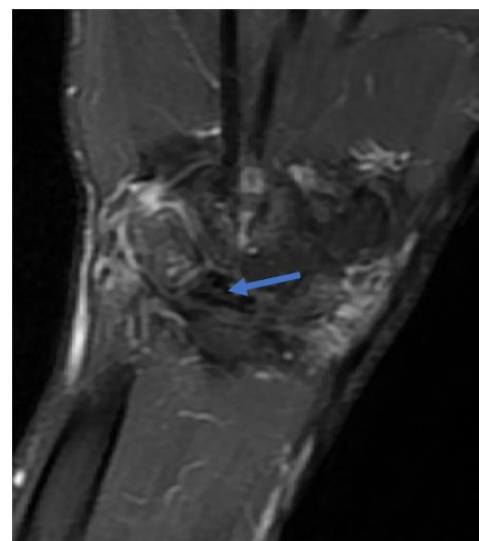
Absence of enhancement on post-contrast T1-weighted images (blue arrow)
